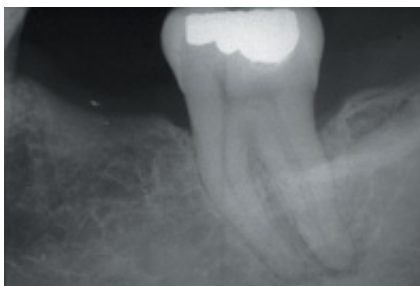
Periapical radiograph of tooth eliciting symptoms.
